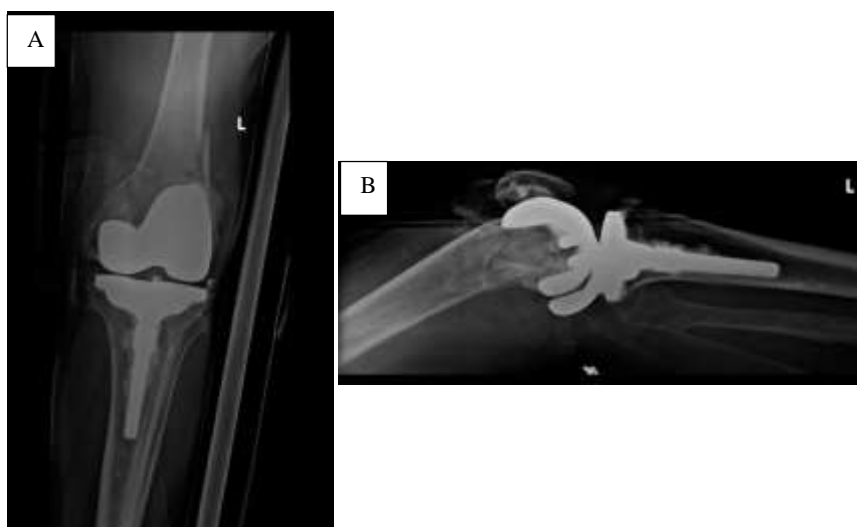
Left knee preoperative radiograph
